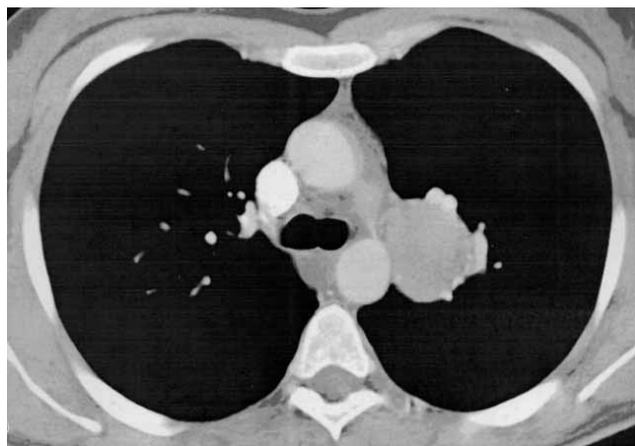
Thoracic computed tomography of a 35-year-old female with a left-sided paraaortic tumour partially calcified in the periphery.
